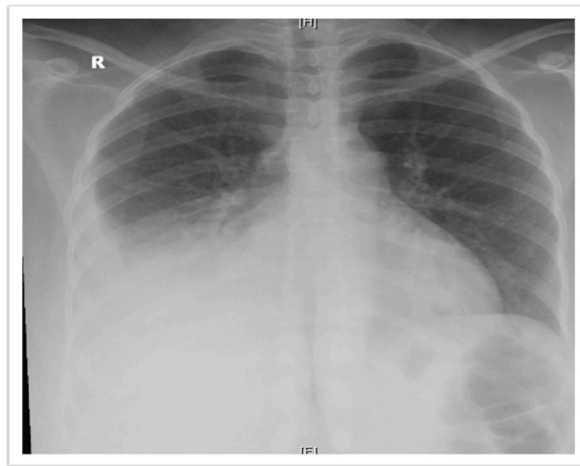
(Initial chest radiography).
